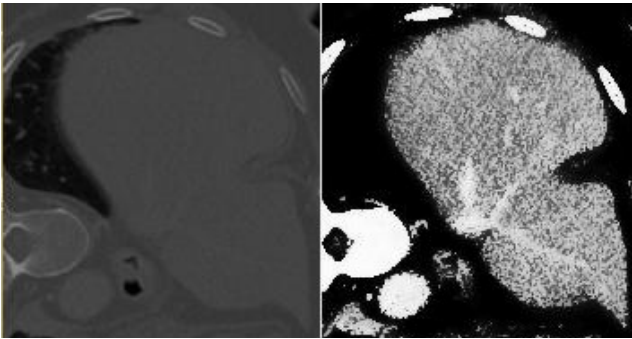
CT slices of the liver before (left) and after (right) filtering
